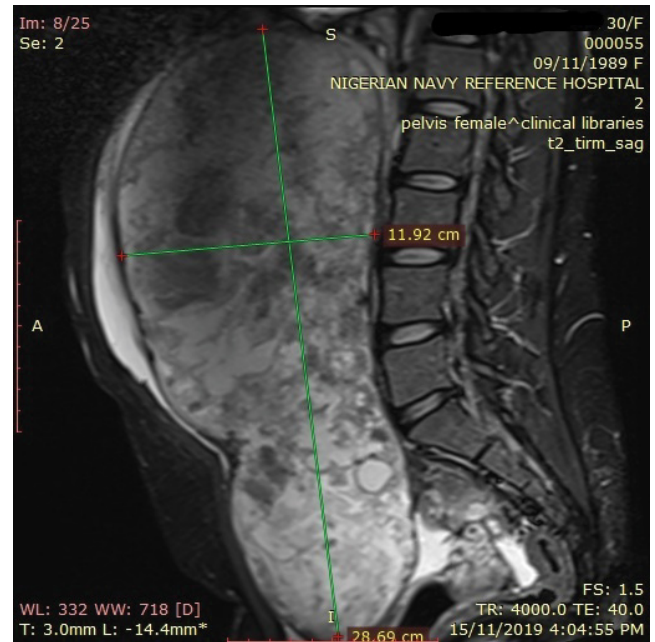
Sagittal T2 FLAIR Magnetic Resonance Image showing grossly enlarged uterus with mixed intensity appearance due to admixture of smooth muscles, fatty elements and areas of cystic degenerations in the mass.
